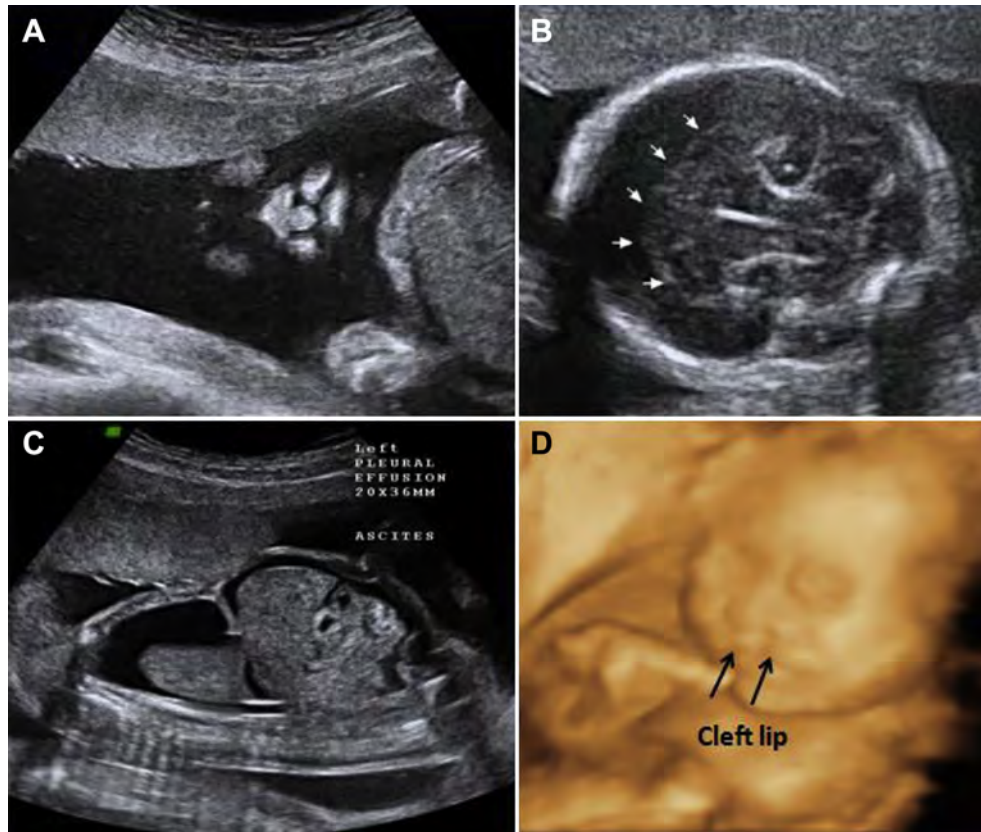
Prenatal ultrasound: (A) Premaxillary dysgenesis: bilateral cleft lip; (B) semilobar holoprosencephaly; (C) hydrops fetalis: ascites and pleural effusion; and (D) fetal facial structure by three-dimensional ultrasound confirmation.
